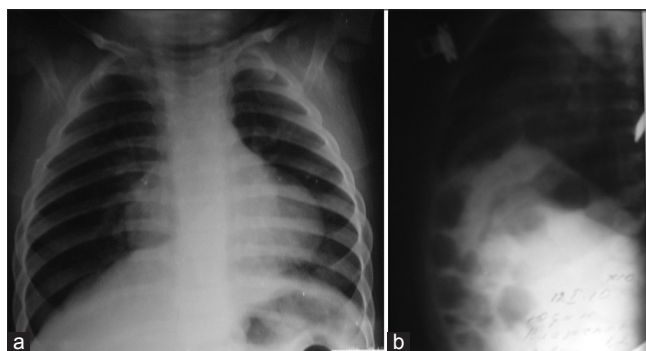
(a) Chest X-ray anterior-posterior (a) and lateral (b) view in 1 year 2 month patient with congenital diaphragmatic hernia of Morgagni. (b) Chest X-ray anterior-posterior (a) and lateral (b) view in 1 year 2 month patient with congenital diaphragmatic hernia of Morgagni
